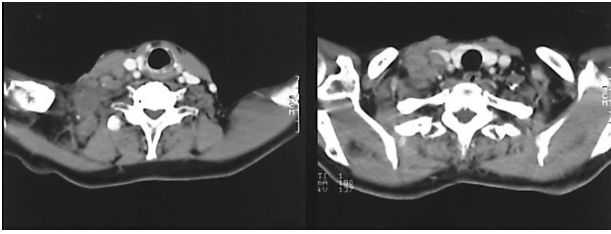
A 76-year-old male with non-Hodgkin's lymphoma. Axial contrast-enhanced CT image at the level of the thyroid gland showing multiple adenopathy in the right neck (*left, middle*). Intense tracer uptake in the right neck is seen in this coronal ^{67}Ga SPECT image (*right*). Confidence in the diagnosis of malignancy by all three readers was improved by adding ^{67}Ga SPECT (from probably malignant to definitely malignant, indeterminate to probably malignant, and possibly malignant to definitely malignant).
